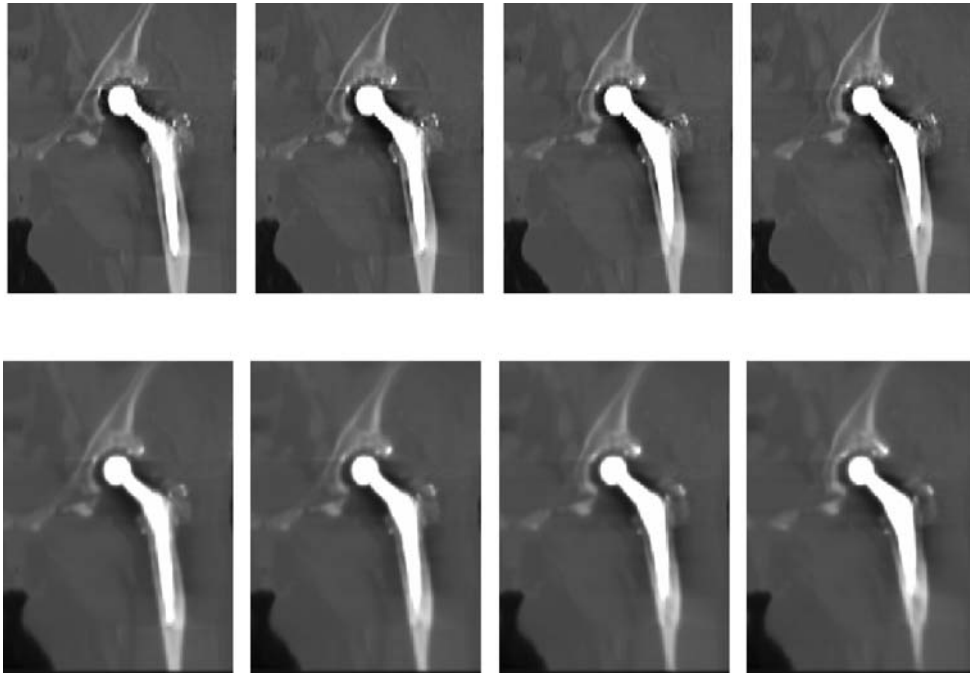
Coronal slice images of the hip prostheses at different heights from MAR-CT and non-MAR CT scans at approximately the same level in Figure 8 (MPR images: 2-mm slice thickness, 2-mm reconstruction interval). The top row shows non-MAR CT images, and the bottom row shows MAR-CT images. Display level (bone information) is the window at 1,000 HU, window level at 300 HU. Remarkable metal artifacts can be seen occurring in the neighborhood of the hip prosthesis.
